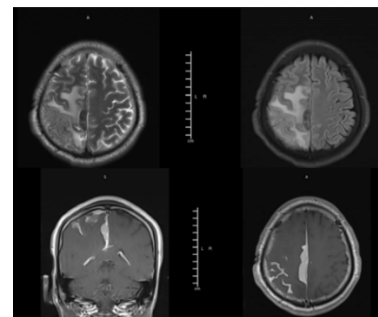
MRI head: Lobulated extra axial Dural based intensely enhancing lesion seen in the interhemispheric flax extending to the right parietal region.
